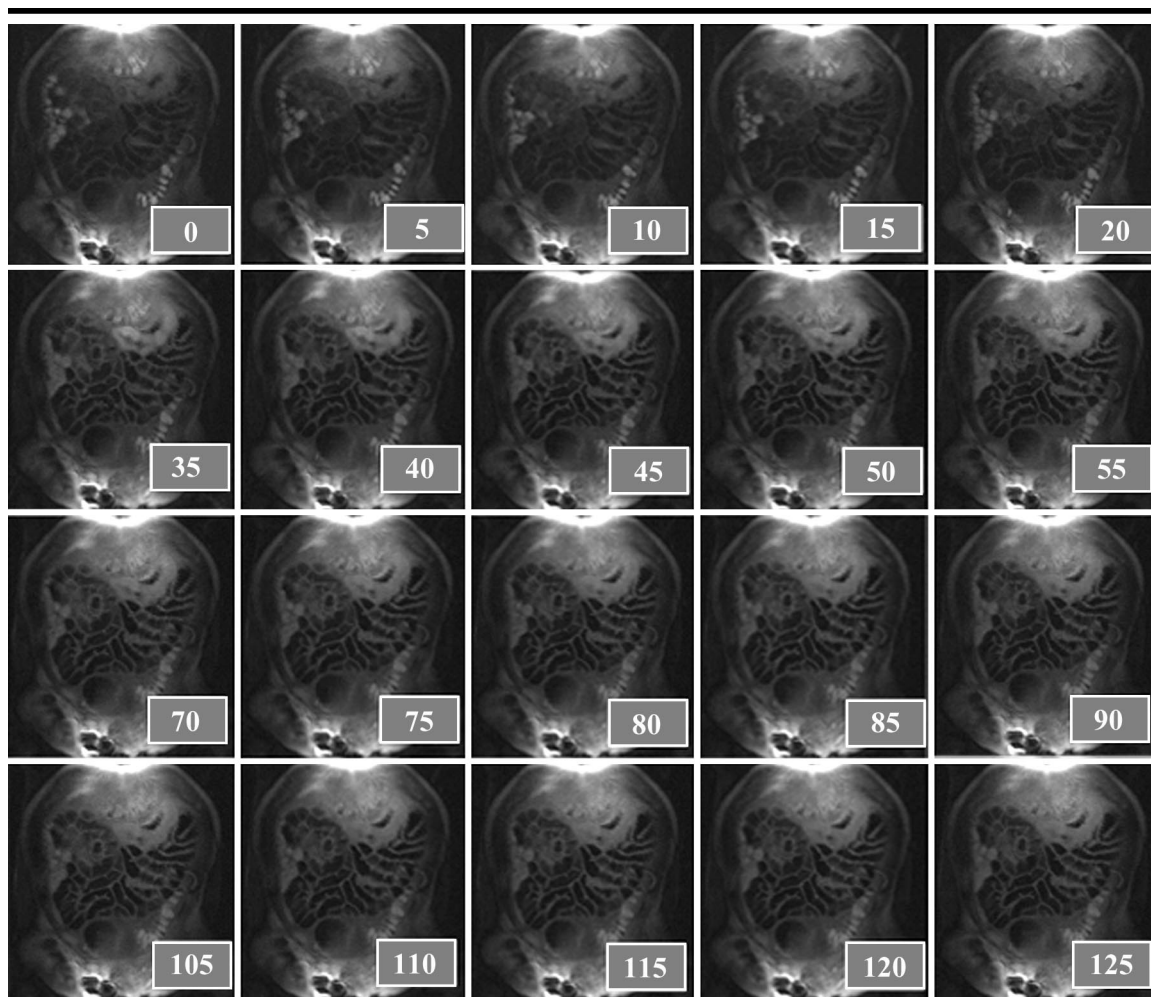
Selected coronal source images from T1-weighted gradient-echo 3D MR imaging data set (3.1/1.2; flip angle, 15°) obtained at all 20 acquisition times in one healthy volunteer, a 24-year-old man. Increasing bowel wall enhancement can be observed within the first 70 seconds. Thereafter, the SNR values in the bowel wall are seen to be in a plateau phase. The numbers in the lower right hand corners of the images represent the time (in seconds) after contrast agent injection at which each image was obtained.
